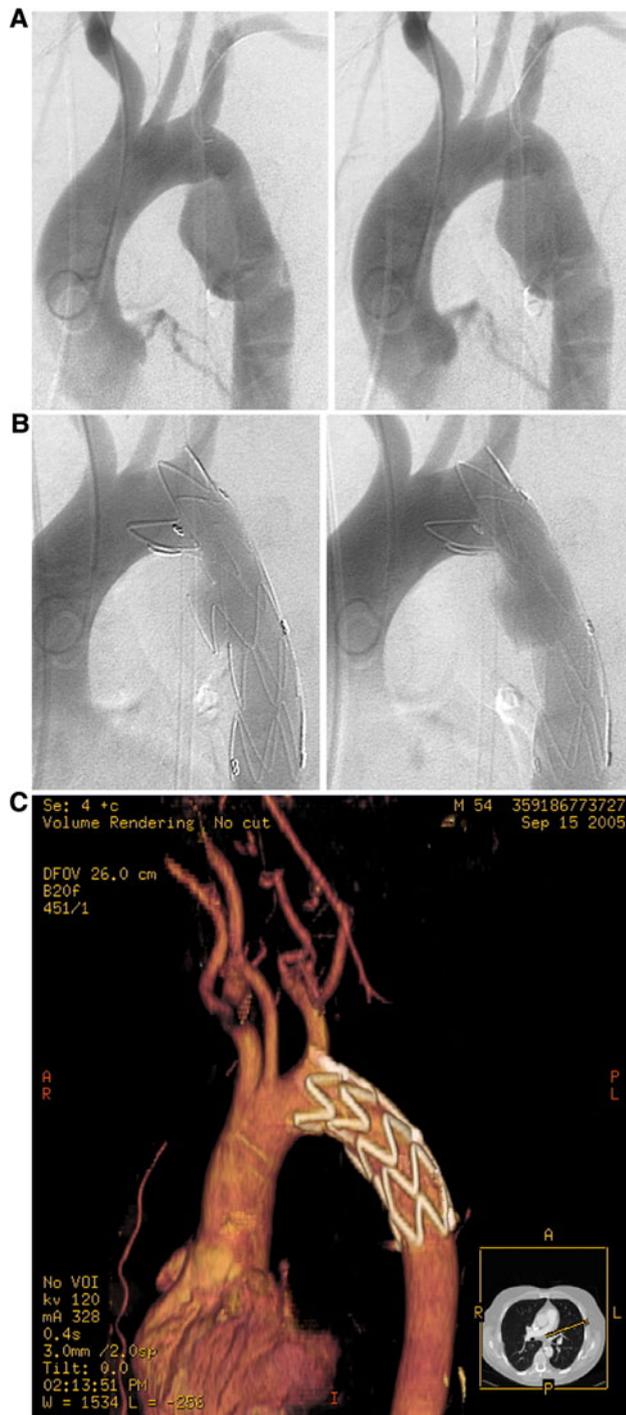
A Angiography in young male patient following high-velocity motor vehicle collision. The conventional angiogram in left anterior oblique projection shows traumatic disruption of the aorta with a pseudoaneurysm formation. B Angiogram following stent-graft deployment shows exclusion of transection from the aortic lumen. We can note a complete expansion of the stent graft opposite the pseudoaneurysm, with relative constrictions at both ends inside the normal aorta. C Five years follow up multi-detector CT scan with 3D-volume rendering reconstruction, shows complete exclusion of the lesion of proximal descending thoracic aorta with adequate remodeling of the aorta
